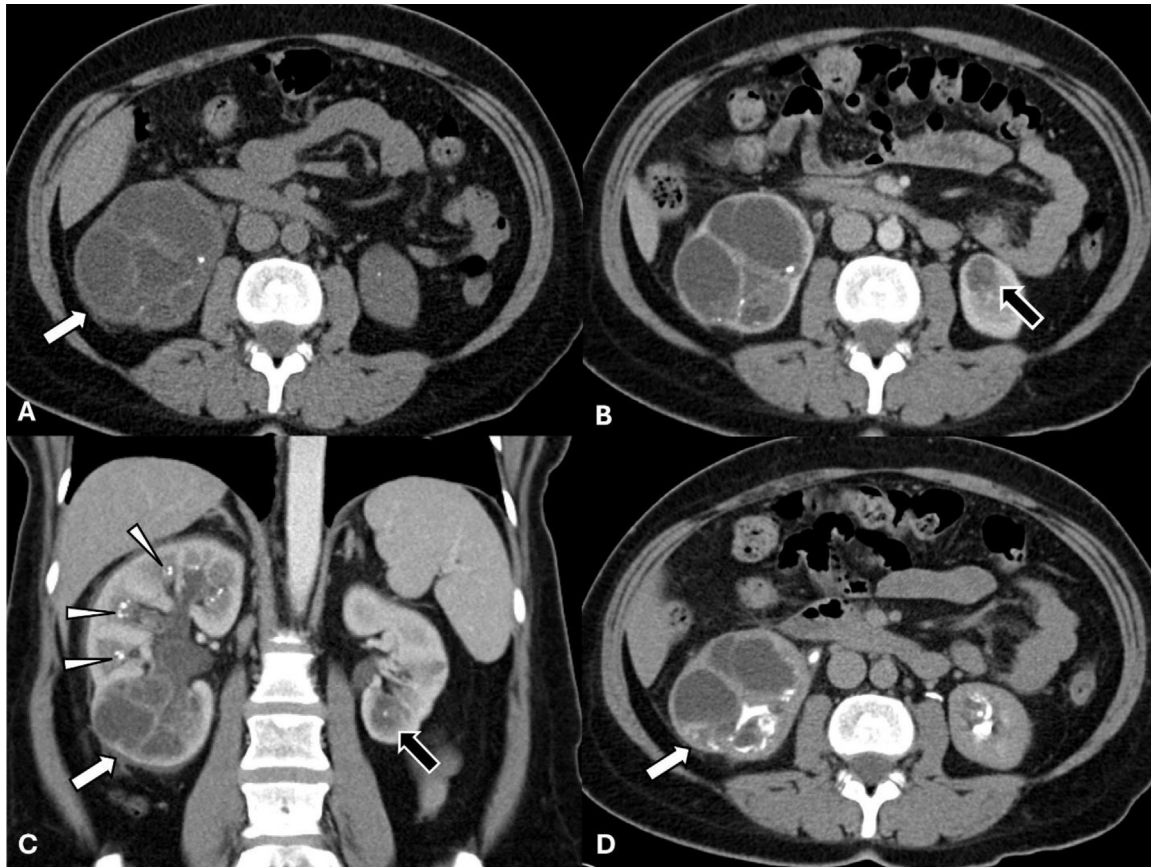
Bilateral MEST in a 49-year-old with history of nephrolithiasis and medullary sponge kidney who presented with flank pain. Computer tomography (CT) urogram demonstrated axial unenhanced (A), axial (B) and coronal (C) nephrographic phase contrast-enhanced, and axial excretory phase contrast-enhanced (D) CT demonstrate multiple right nephroliths (arrowheads) and a multiseptated cystic right lower pole structure with calcifications (white arrows). There is mild hydronephrosis due to a distal right ureteral stone (not pictured). Additional hypodensity in the left renal pole (black arrows) with calcification.
